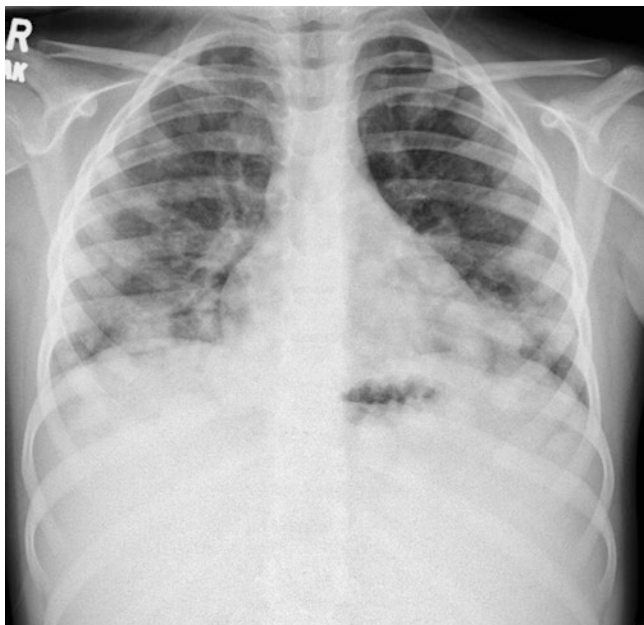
Chest X-ray of a patient with metastatic Wilms tumour. Multiple pulmonary metastases are present
